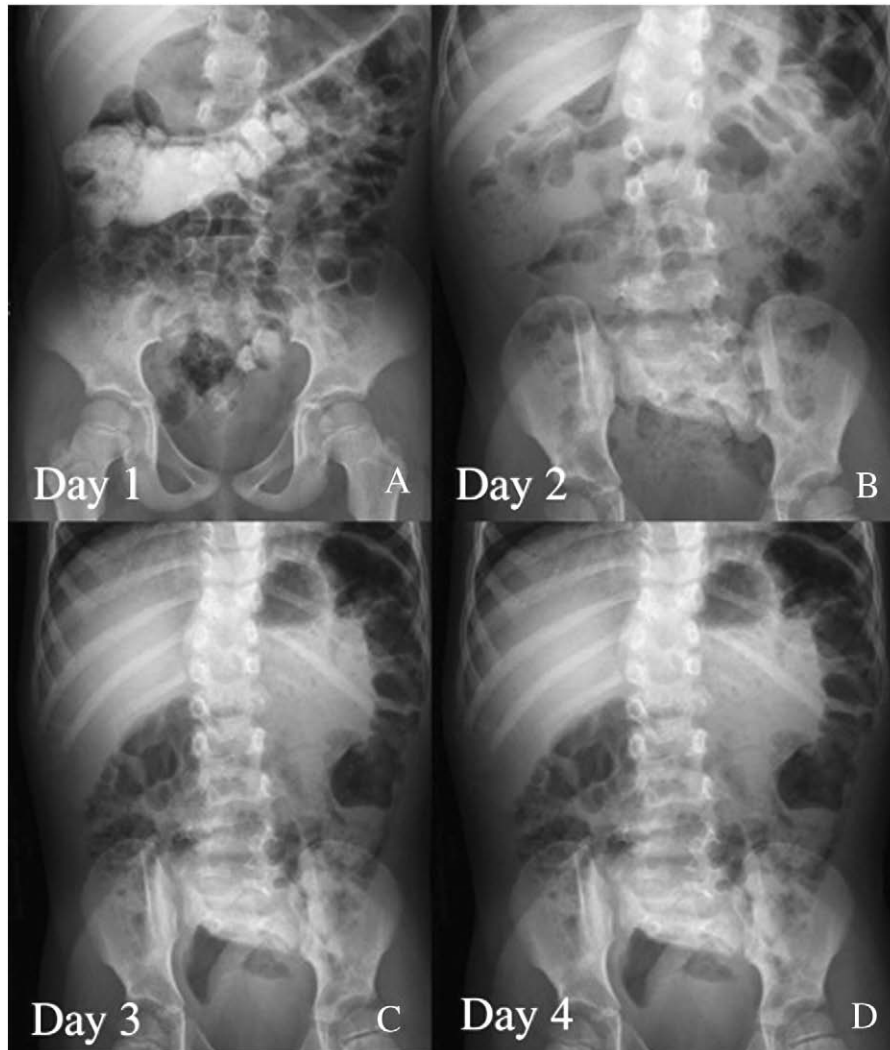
Daily abdominal radiographs to monitor the amount of stool in the colon and the cleaning effect of the prescribed enema.
